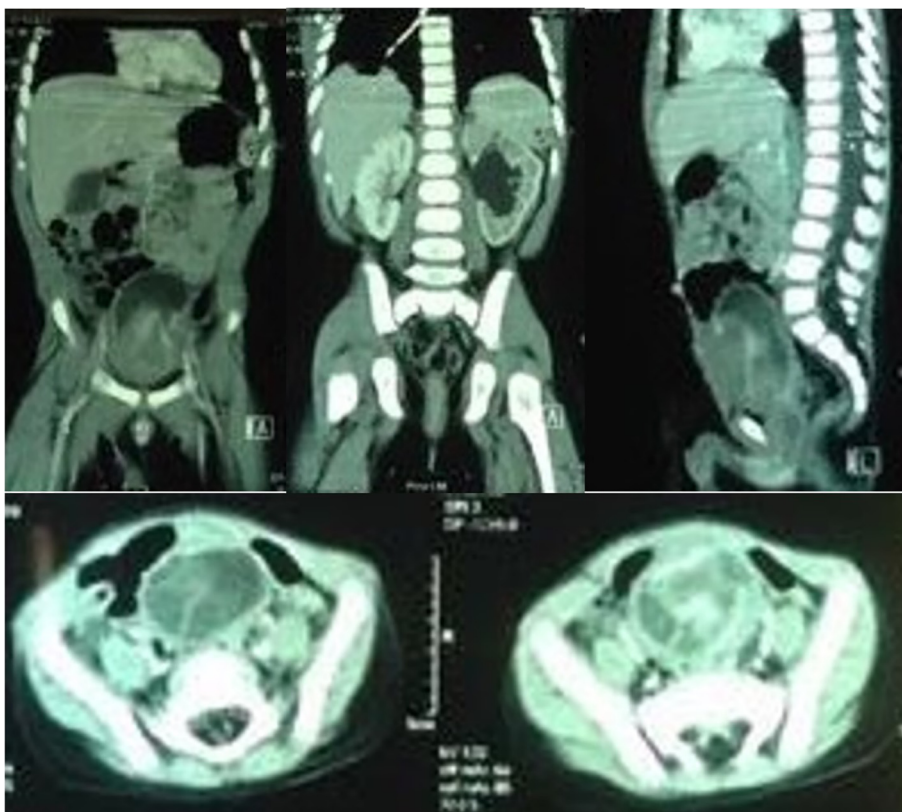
Abdominal-pelvic CT scan revealed dilatation of in left pelvocalyceal system, and mass inside the bladder from anterior bladder wall extending to the prostate and bladder neck.
